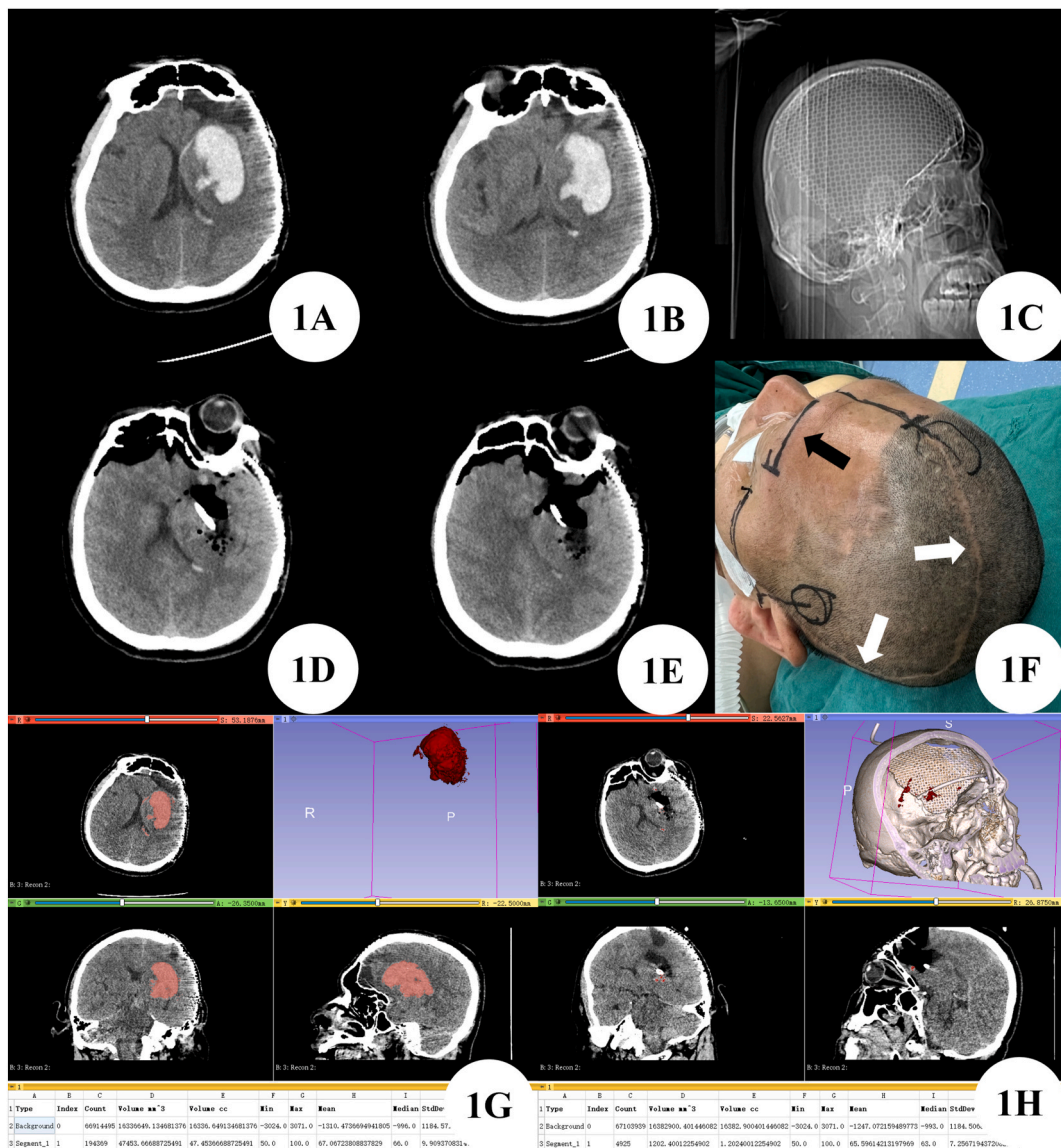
A–B: Preoperative cranial CT shows cerebral hemorrhage in the left basal ganglia area. C: Preoperative cranial CT shows the left basal ganglia area. Preoperative cranial CT shows a large area of metal repair material in the left frontal and temporal skull. D–E: Postoperative cranial CT shows that the hematoma in the left basal ganglia area has been completely cleared. F: Giant original surgical scar (white arrow) and small eyebrow arch keyhole surgical incision marking line (black arrow). G–H: The 3D Slicer accurately calculated the amount of hematoma before and after surgery, and the calculated hematoma clearance rate was 97.47 %.
